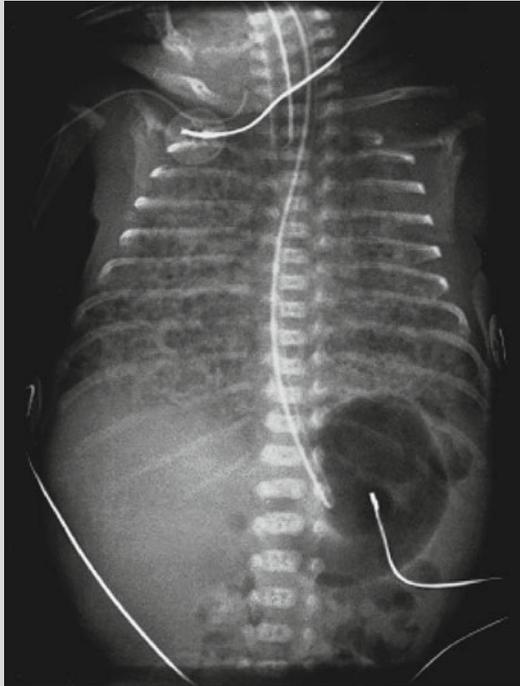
Chest radiographs taken at 15 h of life showing microradiolucencies throughout all lung fields with areas of bullae and hyperinflation
